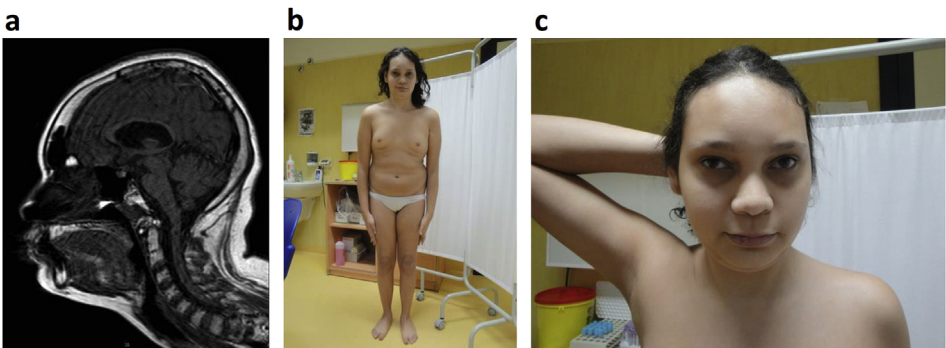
Clinical features of the 26-year-old proband. (a) Brain MRI showing atrophy of corpus callosum. (b) Patient's picture showing large chest, widely spaced nipples, and thin lower limbs. (c) Facial dysmorphisms: high forehead and frontal hairline, wide sparse eyebrows, upslanted palpebral fissures, hypertelorism, squint, long filtrum, thin upper lip.
